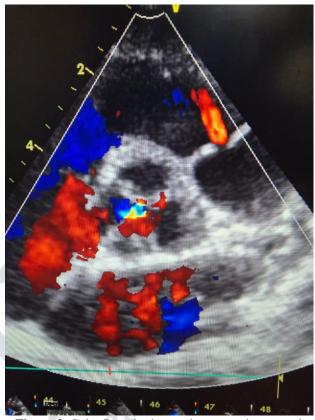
Color Doppler image demonstrating central turbulence at the point of cusp closure, consistent with mild aortic regurgitation
